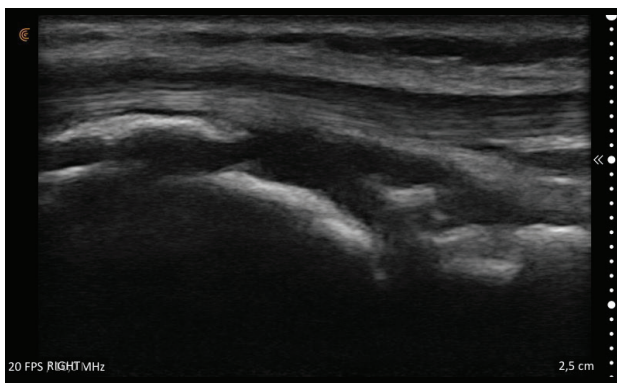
Ultrasound picture of ossification and inflammation of the right knee at the attachment point of the patellar tendon on the tuberositas tibiae.
